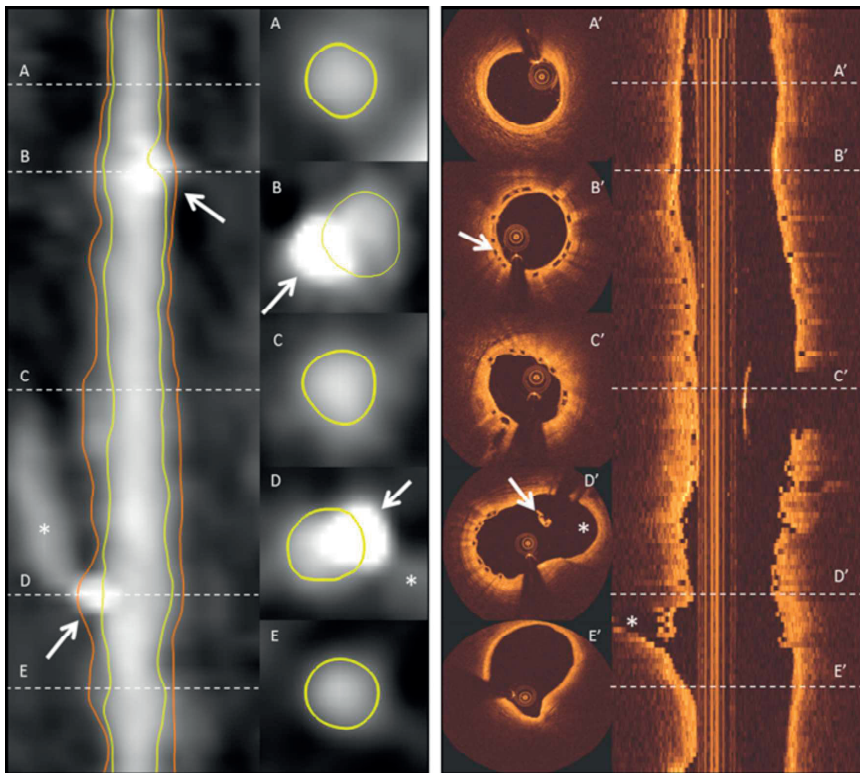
Case example of an coronary CTA straight multiplanar reconstruction image and optical coherence tomography correlating matched luminal areas at the scaffold and non-scaffolded segments. Panels a, a' and e, e' show the vessel lumen at the non-scaffolded segments. Panels b, b' and d, d' show the cross-section at the level of the radiopaque markers, and panel c and c' correspond to the MLA. The MLA with coronary CTA (c) was 3.4 mm^2 and with 4.0 mm^2 with OCT (c'). The markers are shown with white arrows and a white stars identify the sidebranch. CTA computed tomography angiography, MLA Minimal lumen area
